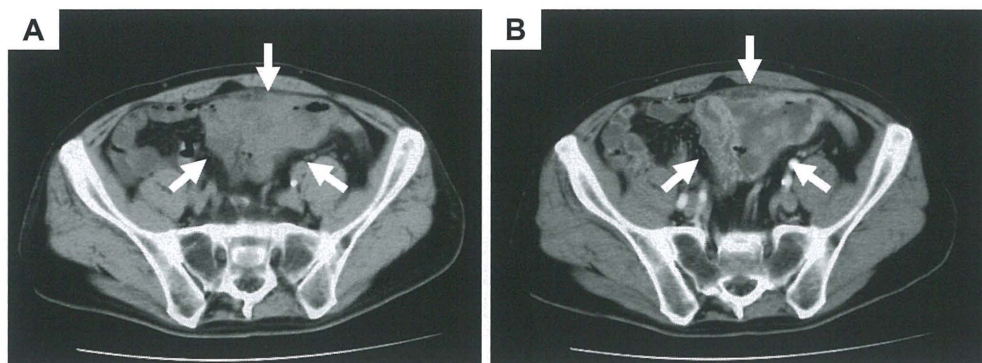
Abdominal CT shows a diffuse thickening of intestinal wall and large tumor (arrows, A: plain, B: enhanced).
